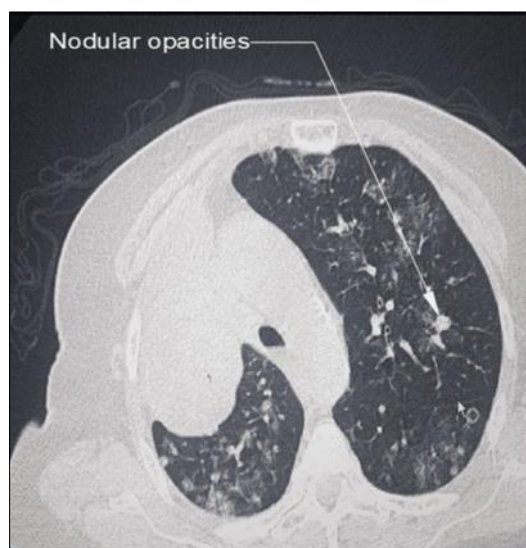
Thoracic CT Scan: Nodular opacities
